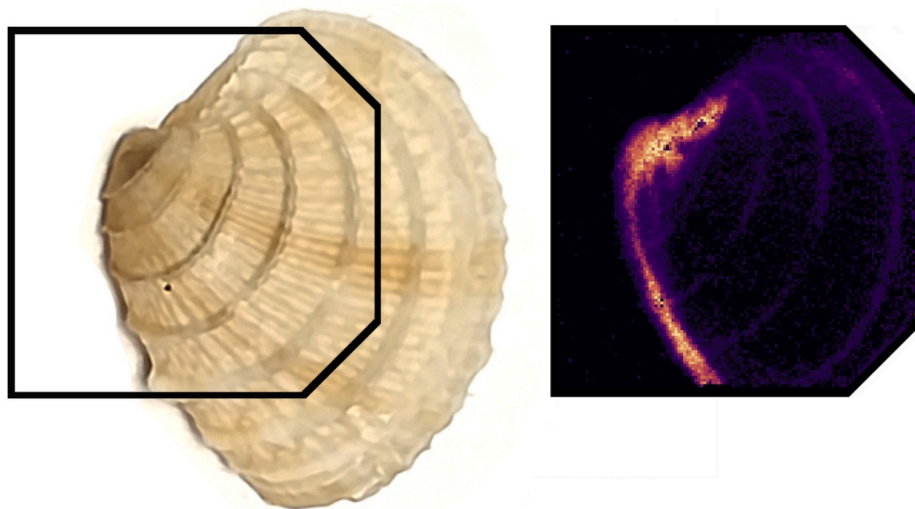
Seashell (a) and its helium ion beam radiography (b). Images by Carlo Amato and Laura Ghesquire-Dierickx, German Cancer Research Center, Heidelberg, Germany (Martišková et al., 2018).
